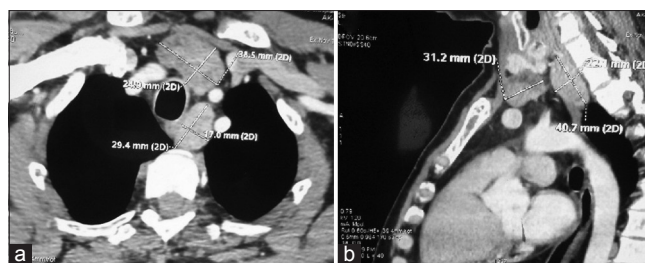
Computed tomography scan of the neck and chest ([a] axial section, [b] sagittal section) revealed two lesions, one in the left upper paratracheal (left inferior parathyroid adenoma) and the other in the pretracheal regions (ectopic mediastinal parathyroid adenoma)
